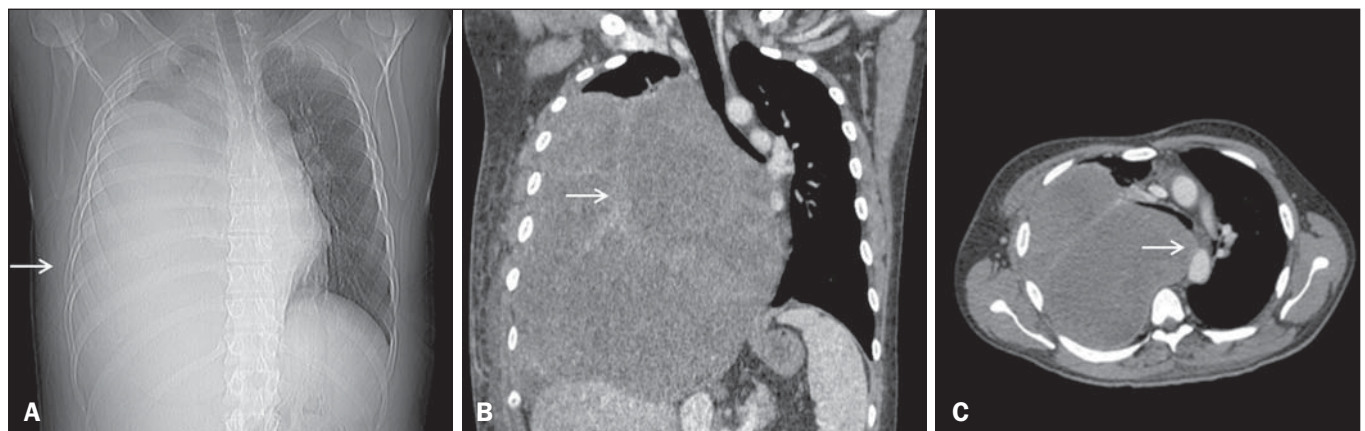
CT scan showing a primary sarcoma in the right hemithorax. A: CT scout image showing opacification of the right hemithorax. B: Coronal CT reconstruction with heterogeneous enhancement (arrow). C: Axial CT slice showing contralateral mediastinal deviation.
